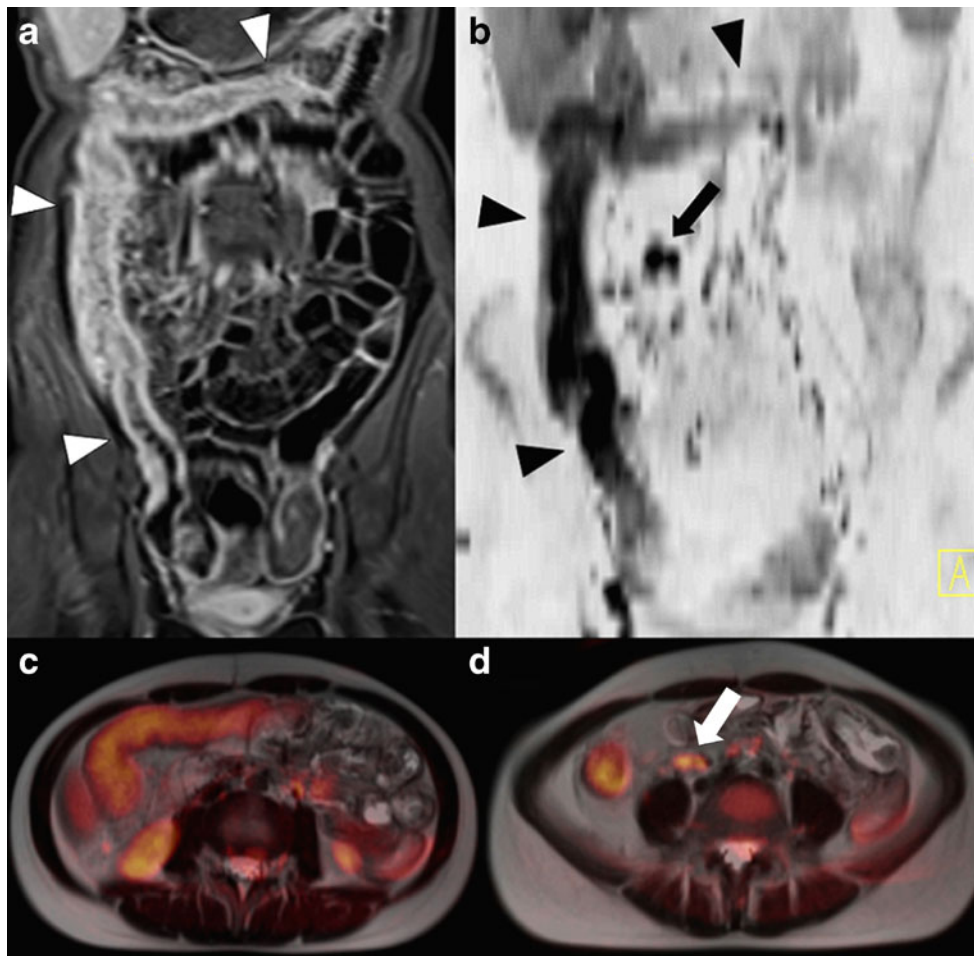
Acute exacerbation of Crohn disease. a, b Inflammatory wall lesions involving the terminal ileum as well as the ascending and transverse colon are clearly discernible (*arrowheads*) on coronal contrast-enhanced T1-weighted images (a curved MPR of coronal T1-weighted 2-D FLASH acquisition with fat saturation, b maximum-intensity projection of $b=800$ DWI, coronal MPR of transverse DWI, inverted grey scale for visual presentation). c, d Fusion of transverse T2-weighted HASTE and coloured $b=800$ DW images at the level of the right colon flexure (c)
